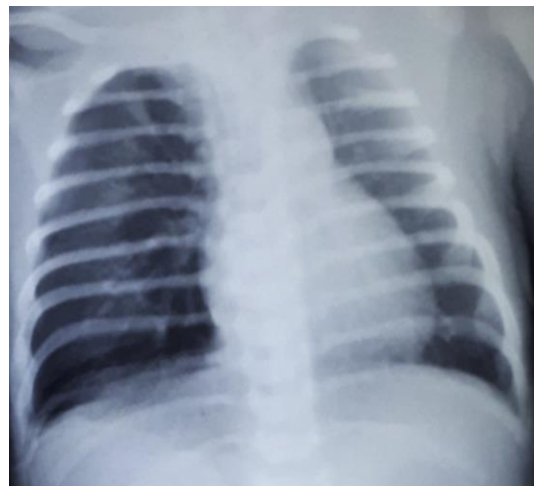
the chest X-Ray of Baby H revealed pneumothorax at right lateral hemithorax
